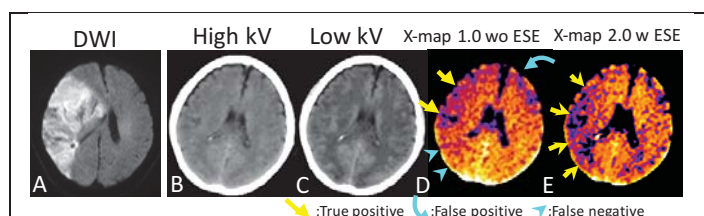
NE-DE-CT was taken 40 min after the symptom onset; DWI 11.5 hours after CT. The color images were generated using “fire” in ImageJ.
